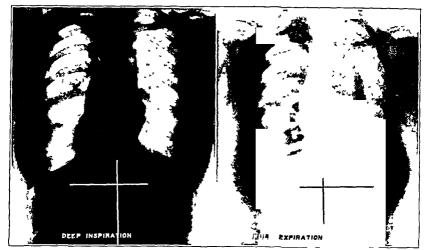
(case 3).—Inspiration and expiration, postero-anterior view of a woman, aged 21. Left-sided pneumothorax induced for progressive unilateral disease with increasing small multilocular cavity formation. Duration of collapse, fifteen months. Amounts of air given from 200 to 400 cc., usually from 250 to 300 cc. Maximum end-pressures given, +4. Sputum gave negative reactions for five months. The roentgenograms show a deviation of the mediastinum to the right of 4 cm. with a slight diminution, 0.5 cm. in the greatest transverse diameter of the heart. Here is most strikingly shown the marked shift in the tracheal bifurcation, which is even greater than that observed in case 2. Note especially the decreased penetration of the rays through the base of the right lung, the appearance of which on forced expiration suggests that seen in atelectasis.
